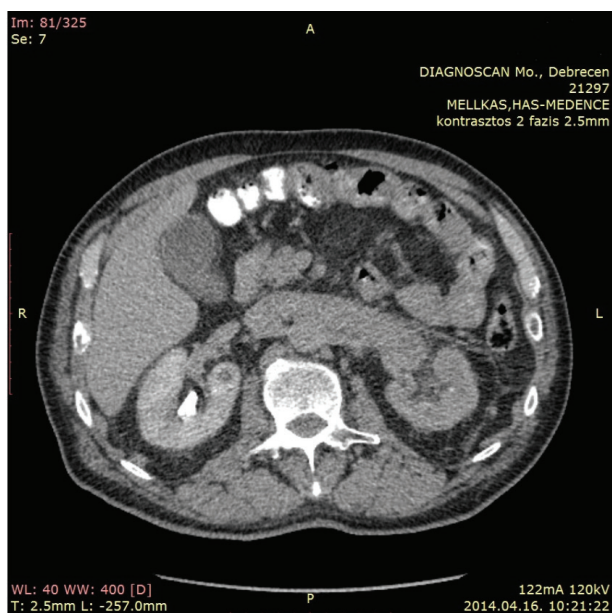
Abdominal computed tomography after the neoadjuvant sunitinib treatment in Case 1 (axial section)
